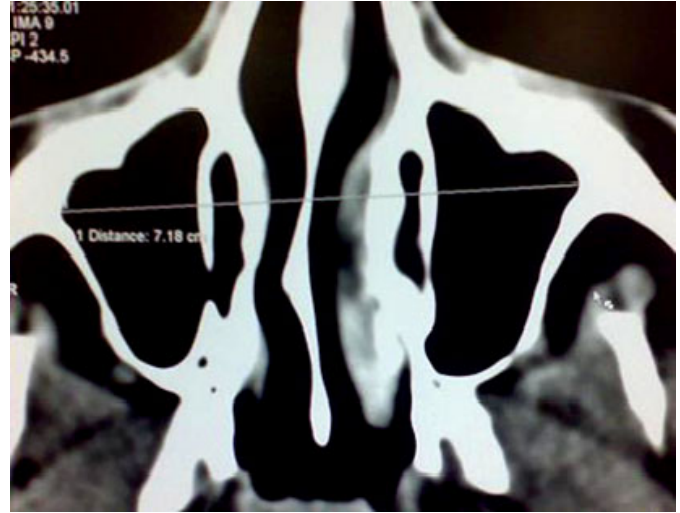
Total distance across both sinuses measured from the reconstructed axial CT section.
